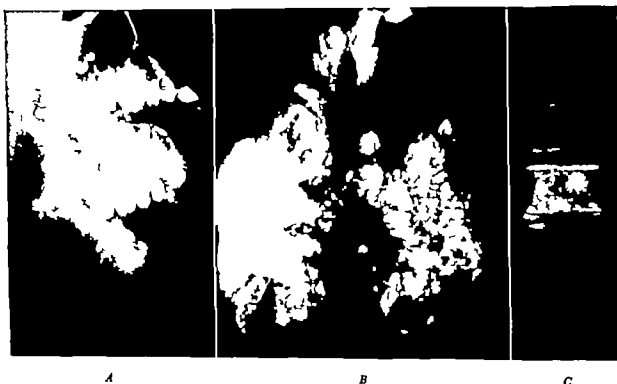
A* Roentgenogram showing local recurrence of osteogenic sarcoma following resection of the mandible. *B* Roentgenogram of the lungs in this case showing extensive metastatic foci of sclerosing osteogenic sarcoma, as observed at autopsy some months later. *C* A focus of osteogenic sarcoma encountered within a lumbar vertebral body in this case. (Additional small tumor foci were also observed in the body of the sternum and in one of the ribs examined.)
